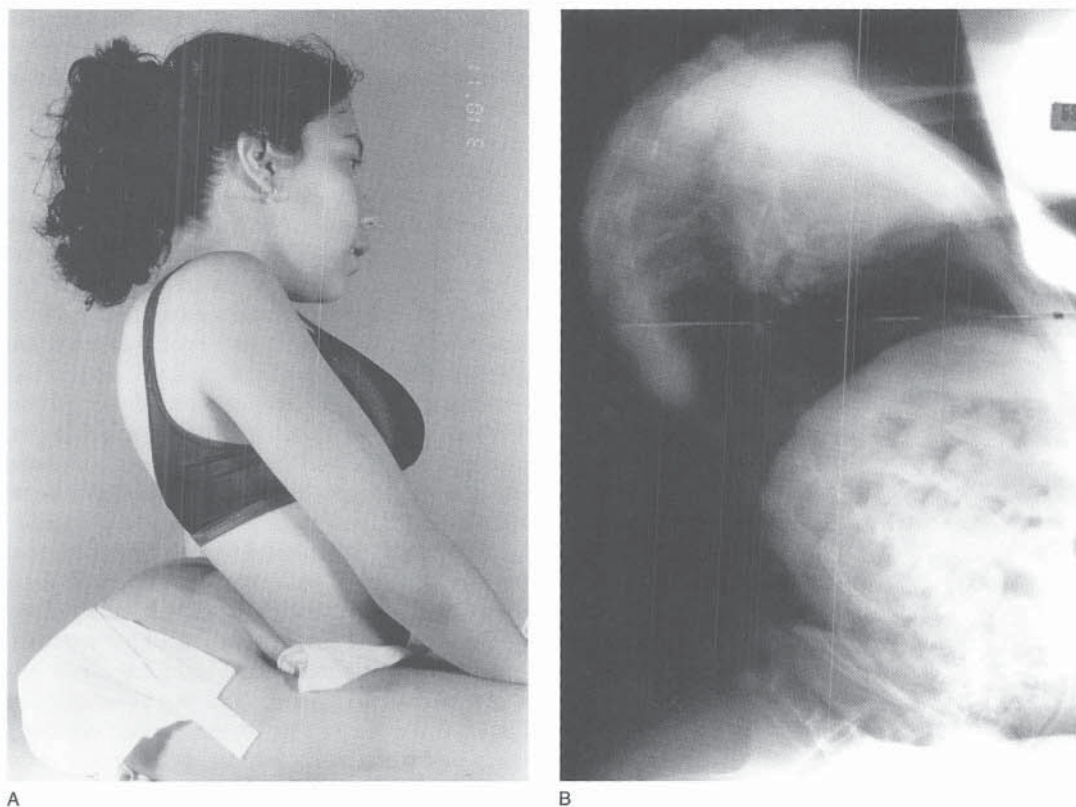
Hyperlordosis in myelomeningocele. A, Clinical appearance. Excessive lordosis can interfere with self-catheterization, particularly in girls. B, Radiographic appearance.
